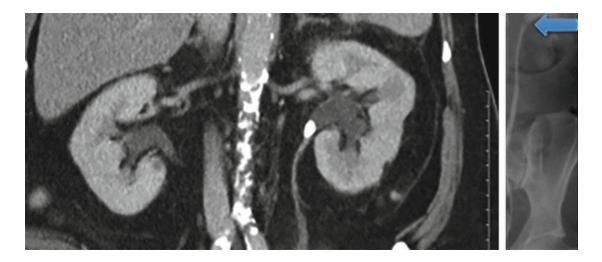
CT demonstrates an obstructing left ureteropelvic junction stone with mild hydronephrosis. Retrograde pyelogram confirms the location of the stone (arrow) before placement of a nephroureteral stent
